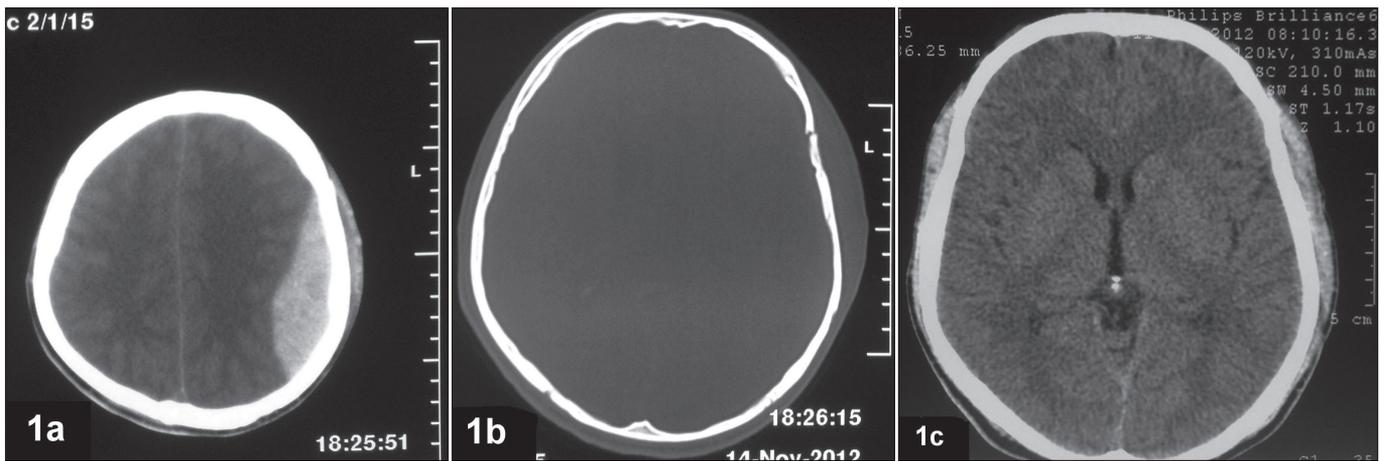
52 years-old male with head trauma secondary to a road traffic accident, having a GCS score at admission of 12; patient was operated on 72 hours after trauma, because of delayed referral in our hospital. (1a) Axial CT scan showing a left fronto-parietal EDH, with midline shift; (1b) axial CT bone window, showing a left fronto-temporal fracture; (1c) axial CT scan performed 45 days after surgery, showing complete resolution of the EDH.
